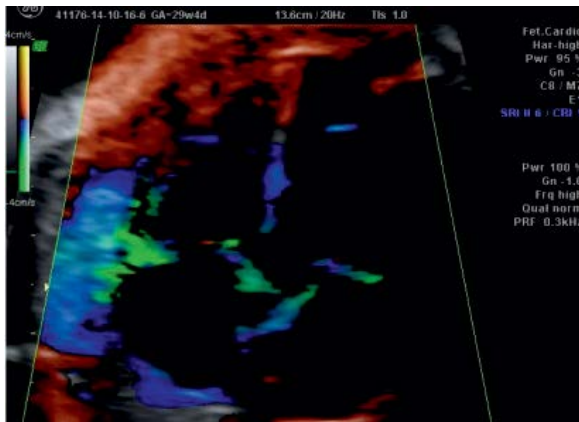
Doppler imaging view
